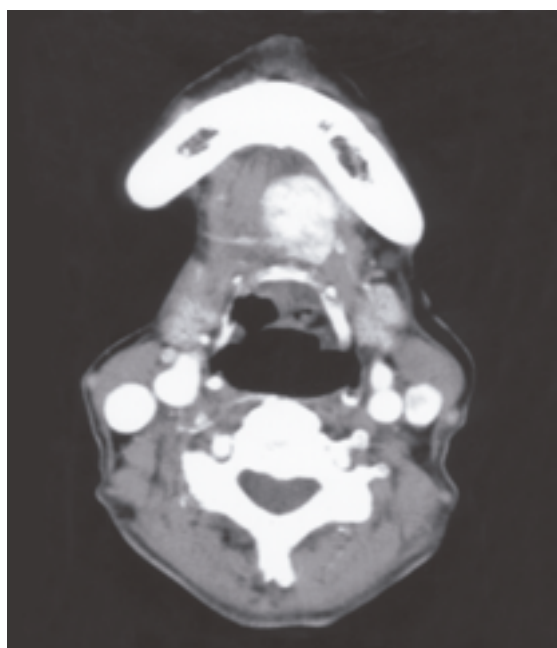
Enhanced axial CT image of the upper neck.
